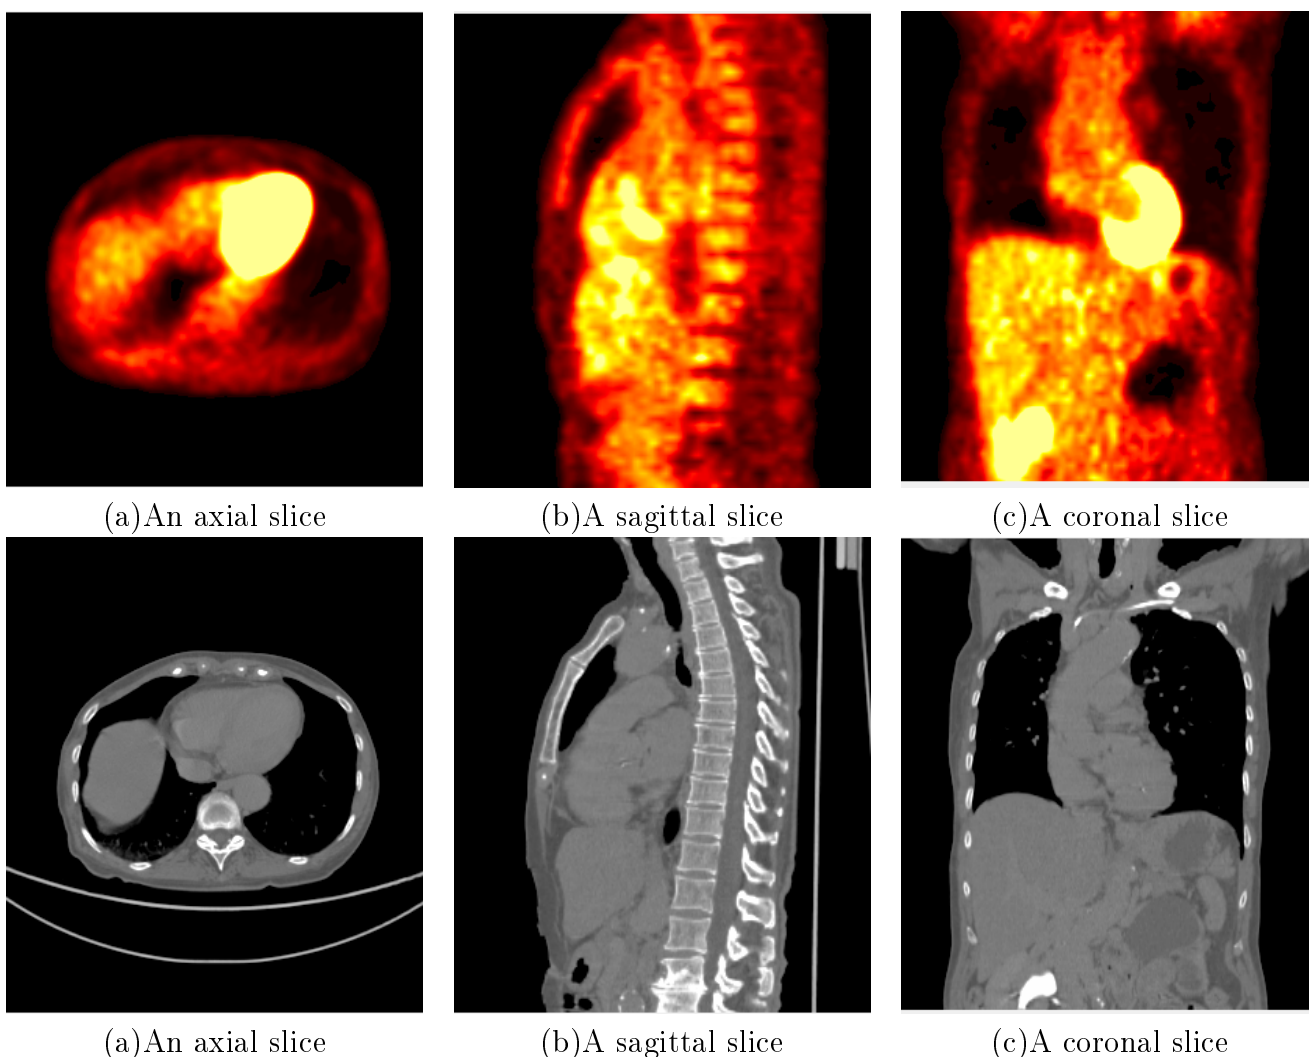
An example of an attenuation corrected PET image (top row) and AC-CT (bottom row).
